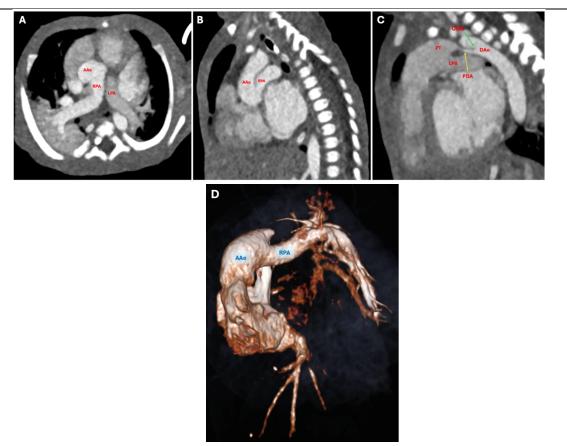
Cardiac CTA result (24/06/2023, at 59-day-old). A, Axial view of MDCT angiography reveals right pulmonary artery (RPA) originating from ascending aorta (AAo) with left pulmonary artery (LPA) arising normally from main pulmonary artery. B, Sagittal view shows RPA branches from the AAo and cardiomegaly. C, The anomaly was accompanied by the presence of PDA (yellow arrow) and discrete coarctation at DAo at Thoracic 3 level (green arrow). D, Three-dimensional volume rendering technique (3D VRT) image shows RPA arises
